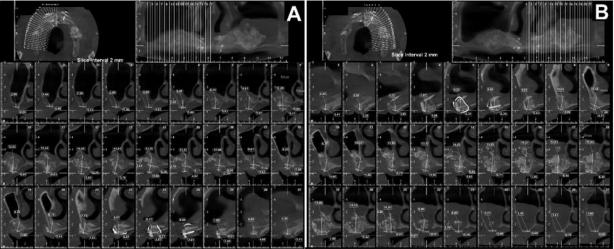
Six months CBCT shows adequate height and width of anterior and posterior maxillary bone (augmented and native alveolar bones totally) for implant placement. (a) Right side of maxilla (b) Left side of maxilla.
